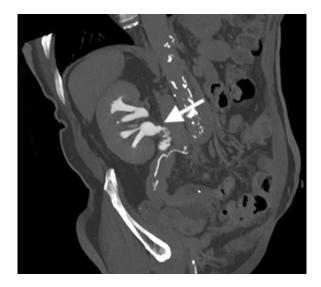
Coronal oblique MIP reconstruction of a CT Urogram. The patient underwent cystectomy, left sided nephroureterectomy and right ureterectomy for upper tract TCC. Due to the ureteric involvement the surgeons have directly anastomosed the ileal conduit to the right renal pelvis as indicated by the arrow.
